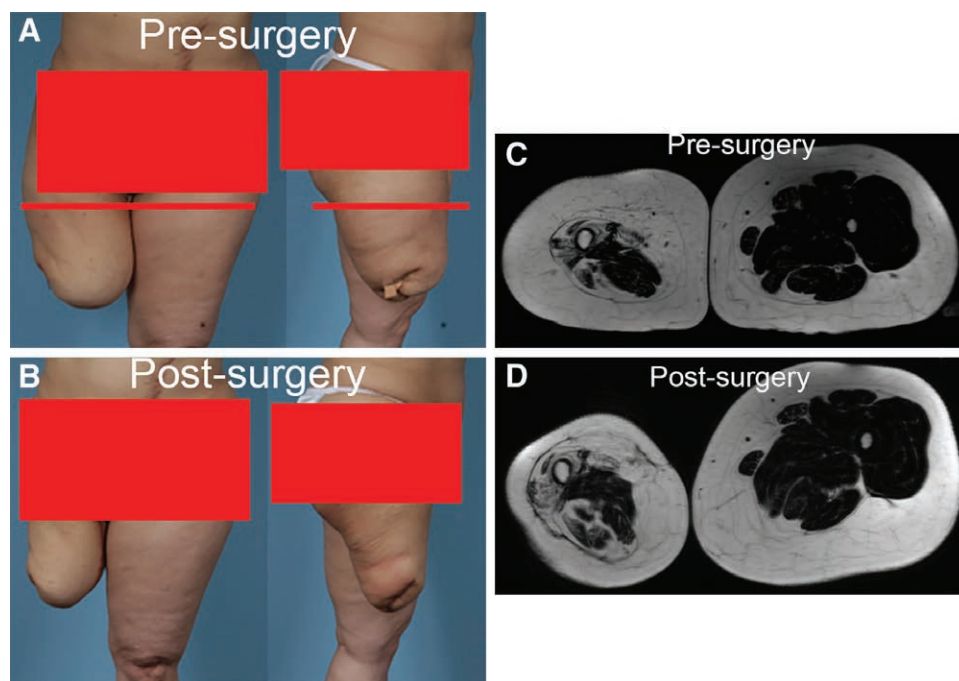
Surgical and MRI images. (A and B) Pre- and post-surgical photographs of the patient. The limb became narrower and a bit shorter as distal tissue was removed. (C and D) Pre- and 5-month postsurgical MRIs captured mid-length of the residual limb at the level shown with the red bar.
